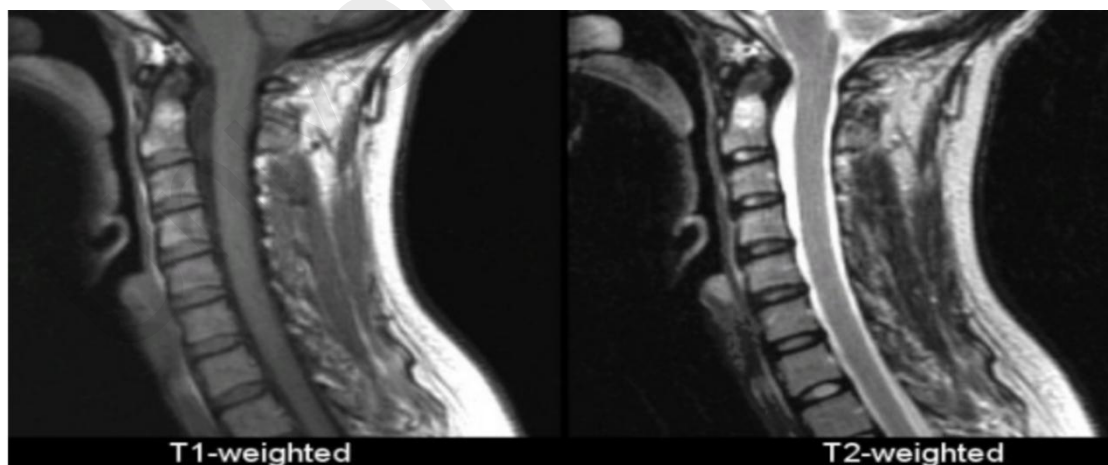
5 A MRI images (brain) from patient
